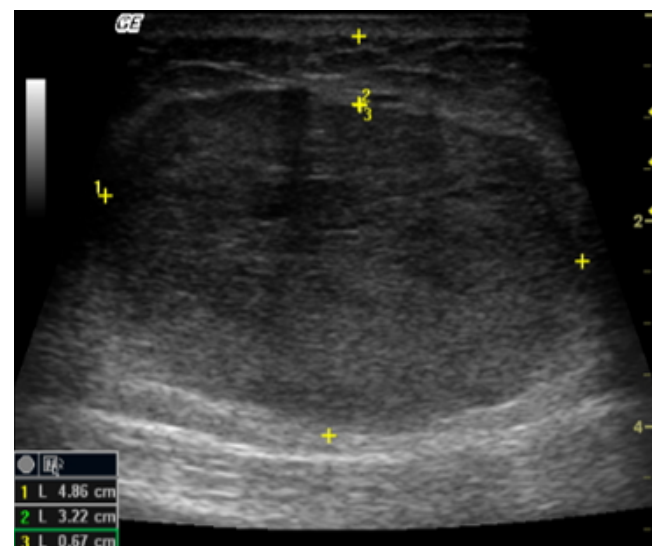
Case 1: ultrasonography shows a circumscribed, oval nodule, parallel to the skin.
